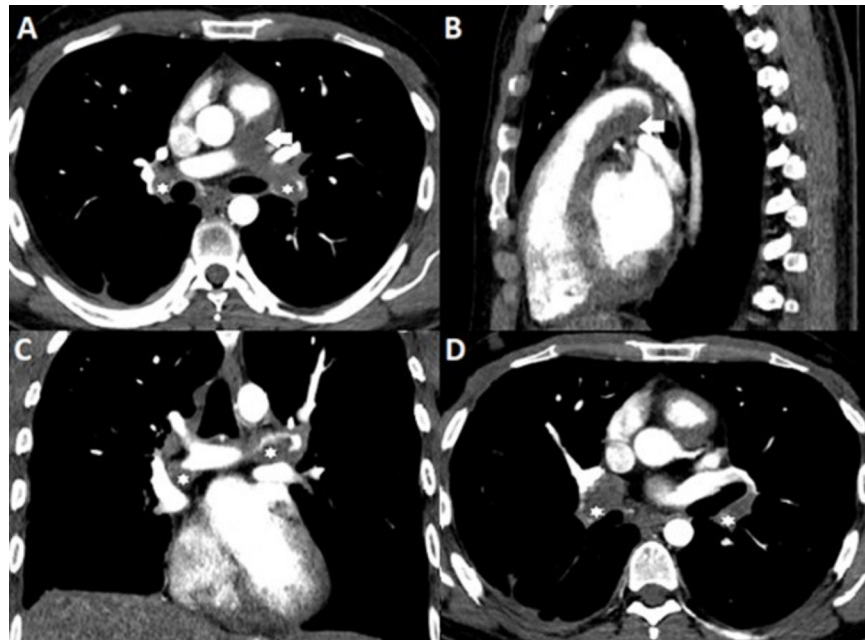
Pulmonary CT angiography findings. A and D axial, B sagittal, C coronal images. Filling defects in the main pulmonary artery (arrow), in both pulmonary arteries, with extension in the bilateral lower lobar artery (Asterix).
